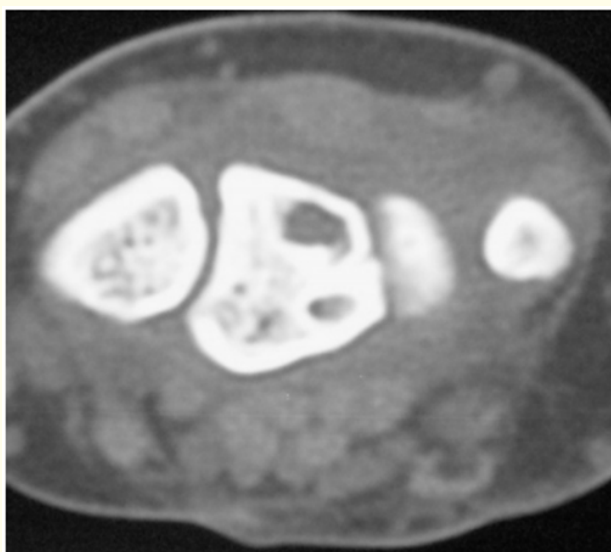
Wrist CT scan: Highlighting lacunar images on the semilunar bone.
